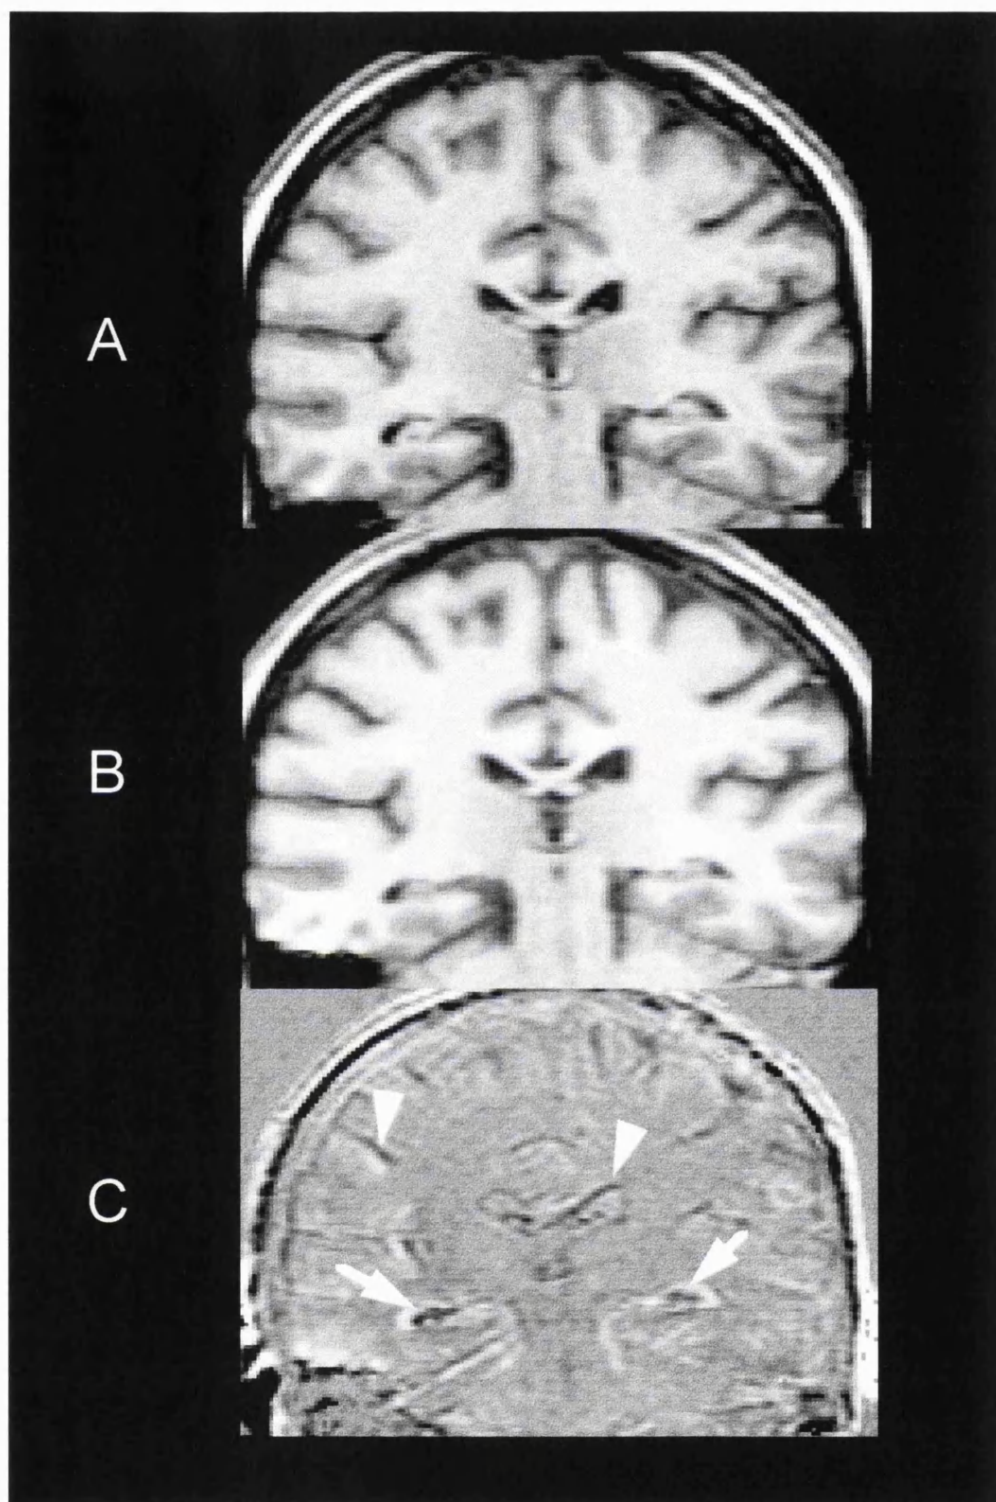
Registration of brain scans using Mrreg. A Coronal T1-weighted image obtained 1 year after status epilepsy. B Coronal T1-weighted image obtained 4 years later and registered to A. C Difference image ($B - A$). Dark pixels indicate loss of signal intensity (atrophy) between A and B. Atrophy is visible in both hippocampi (arrow). There is also mild ventricular expansion (arrowhead). Only minor neo-cortical and ventricular changes are visible (arrowhead). Windowing in C: level=0, width=100.
